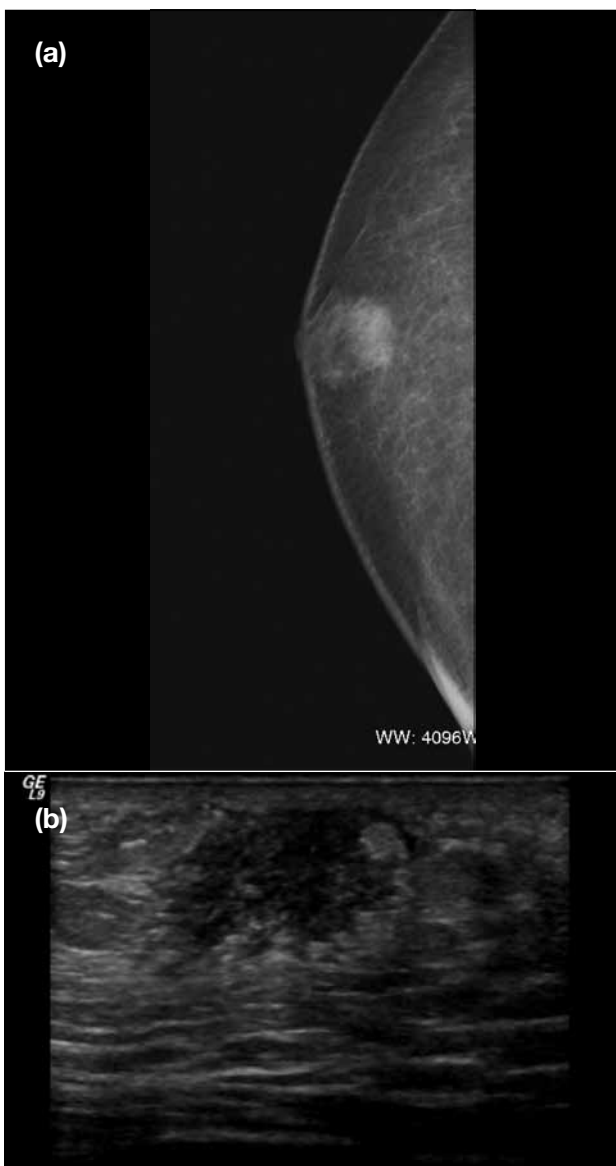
Early nodular gynaecomastia: (a) Craniocaudal mammogram reveals a nodular retroareolar density. (b) Supplementary ultrasound shows a retroareolar fan-shaped hypoechoic nodule surrounded by normal fatty tissue.
